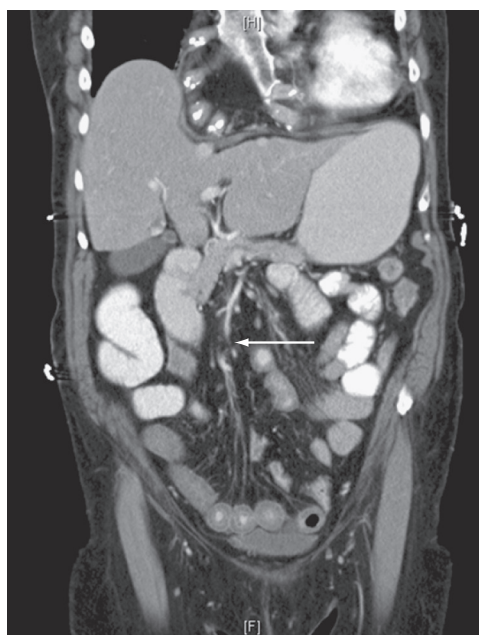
■ Computed tomography after administration of oral and intravenous contrast in a patient with an embolism to the superior mesenteric artery and ischemia of the small bowel and right colon. The arrow points to the embolus in the superior mesenteric artery.
